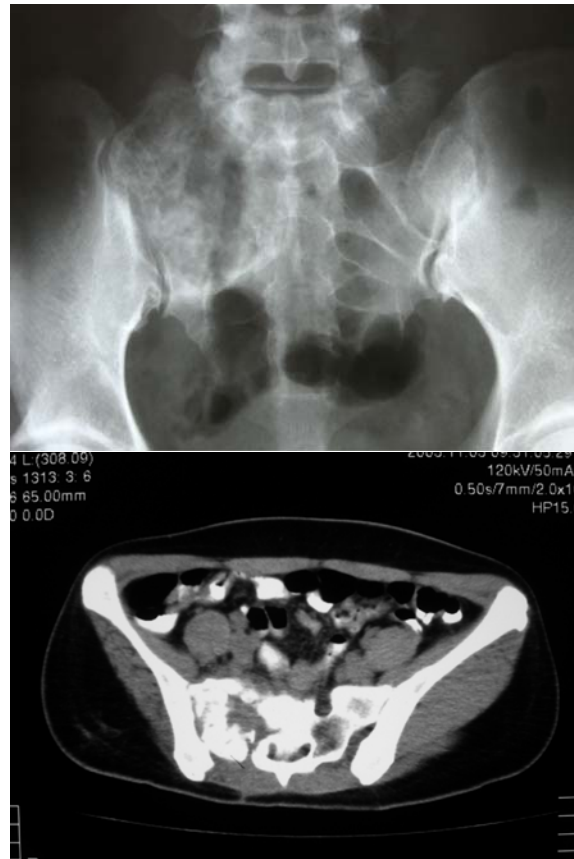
Radiographs of the sacrum. The radiograph showed sclerosis at the lesion after received intravenous zoledronic acid 4 mg every 4 weeks for 4 courses
